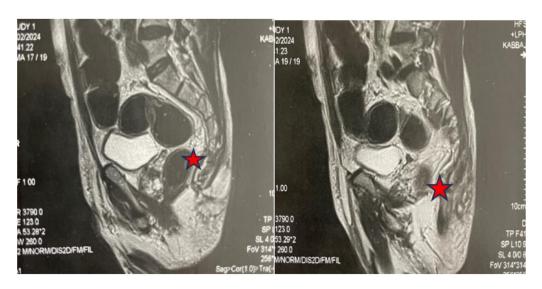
Pelvic MRI shows pericoccygeal collection with soft tissue involvement and fistulous tract (stars)
